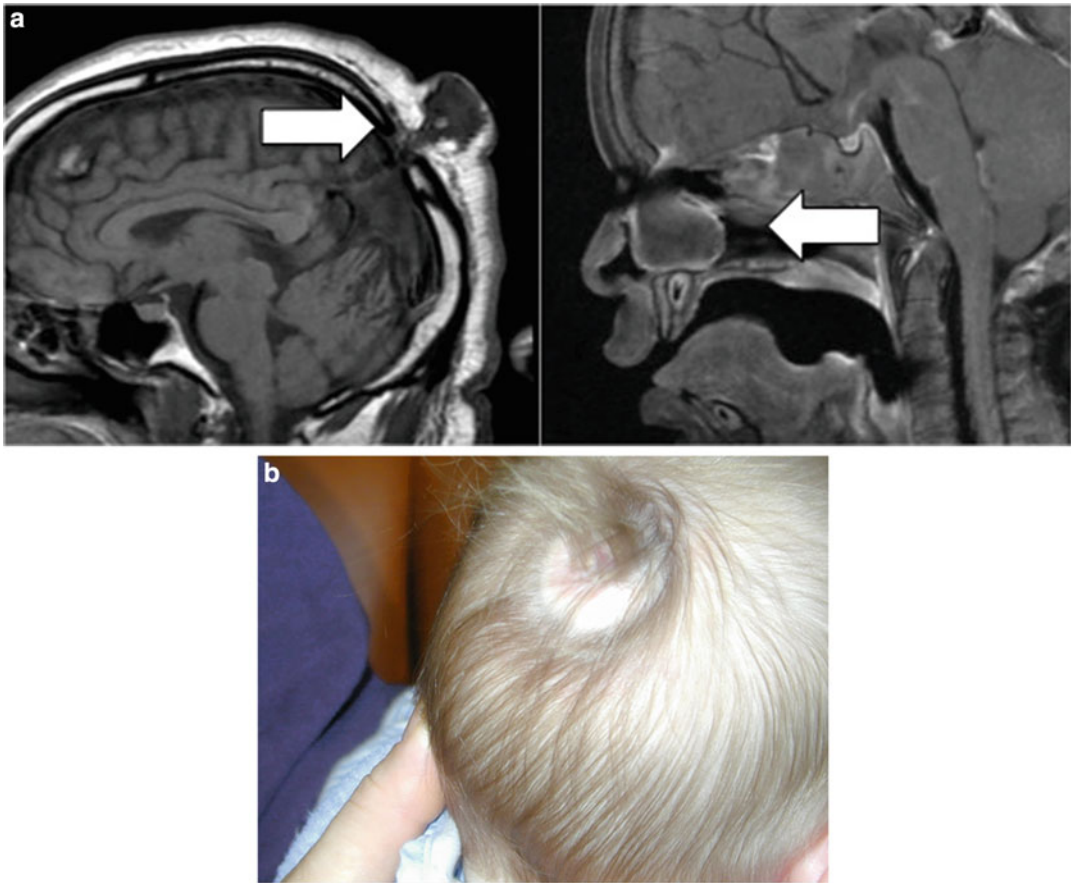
(a) Encephaloceles: Atretic parietal encephalocele (*left*), and foramen cecum encephalocele (*right*) on sagittal T1-weighted magnetic resonance imaging. (b)
